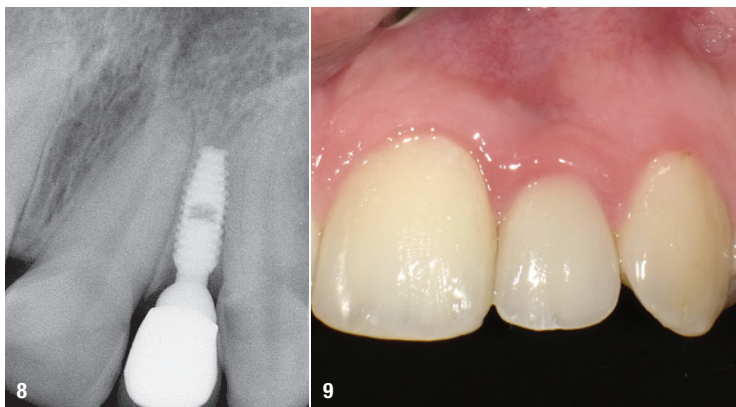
Final radiographic control after three years of function. Note the platform switching between the neck of the implant and the hemispherical base of the abutment. Fig. 9: Intra-oral control of the crown and surrounding soft tissue at three years. Note the stability of the papillae, being supported by bone formed over the sloping shoulder.
